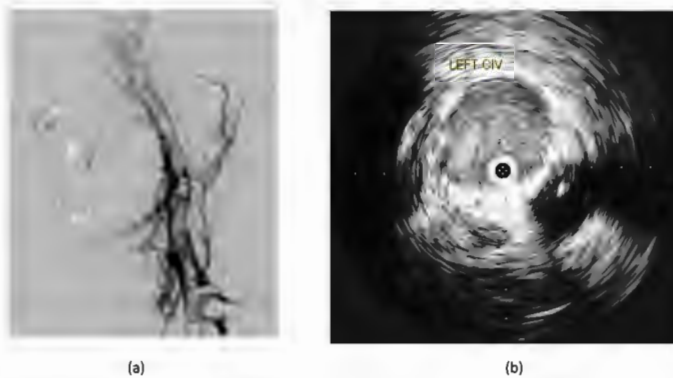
(a) Acute iliofemoral deep vein thrombosis (DVT) noted by venography. Early collateralization and multiple venous filling defects are noted, (b) Common iliac vein seen with intravascular ultrasound showing dilated appearance and significant thrombus burden.
